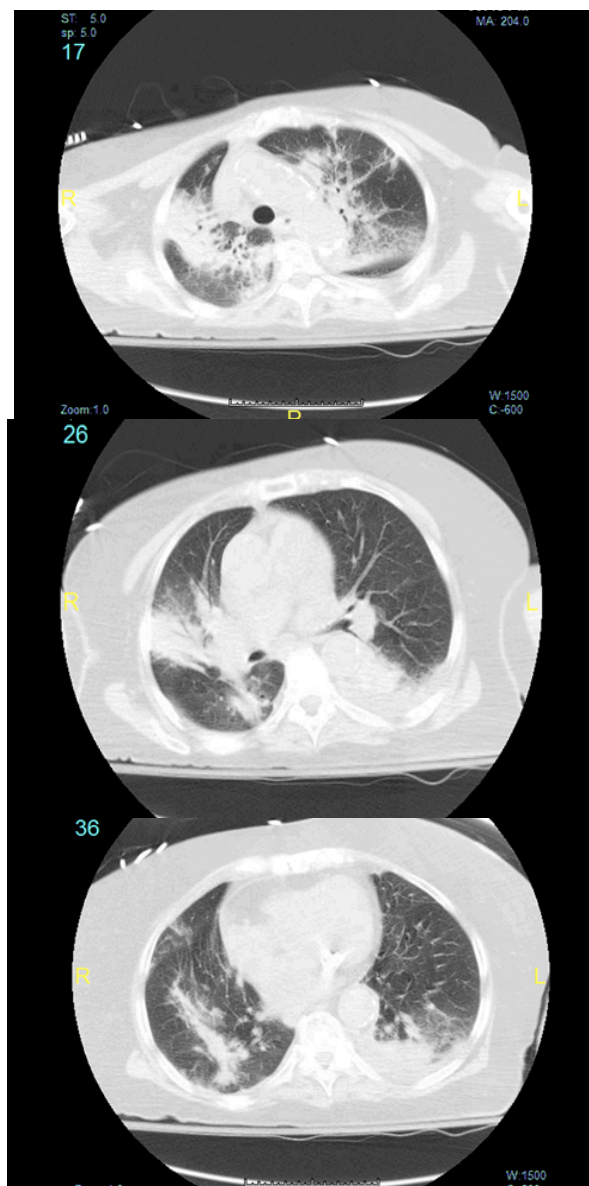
Chest CT scan confirming multifocal pneumonia during hospital admission with deterioration of patient symptoms.
